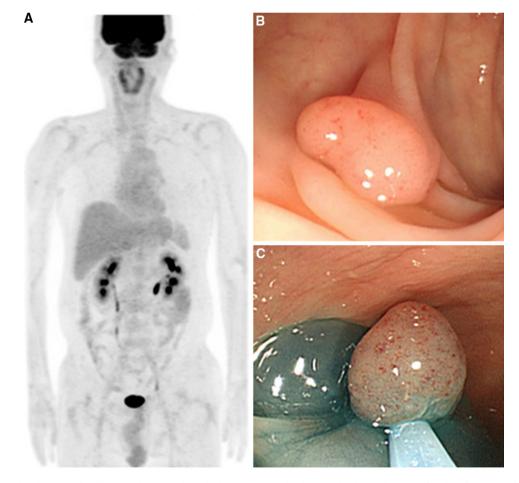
Representative images of a 50-year-old man with tubular adenoma with low grade dysplasia are defined as false-negative.  $\mathbf{a}$  Any focal FDG uptake was not seen on FDG PET image.  $\mathbf{b}$  and  $\mathbf{c}$  A 1.5 cm sigmoid colon polyp was seen in colonoscopy and performed polypectomy
